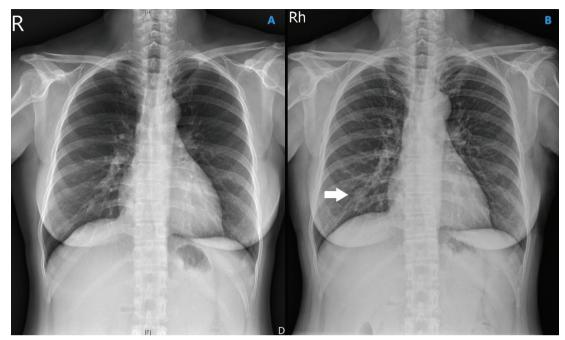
Patient's chest X-ray. (A). March 2018. (B). August 2021. Compared with the earlier chest X-ray, the more recent chest X-ray shows a nodular opacity at the right lower lung (white arrow).
